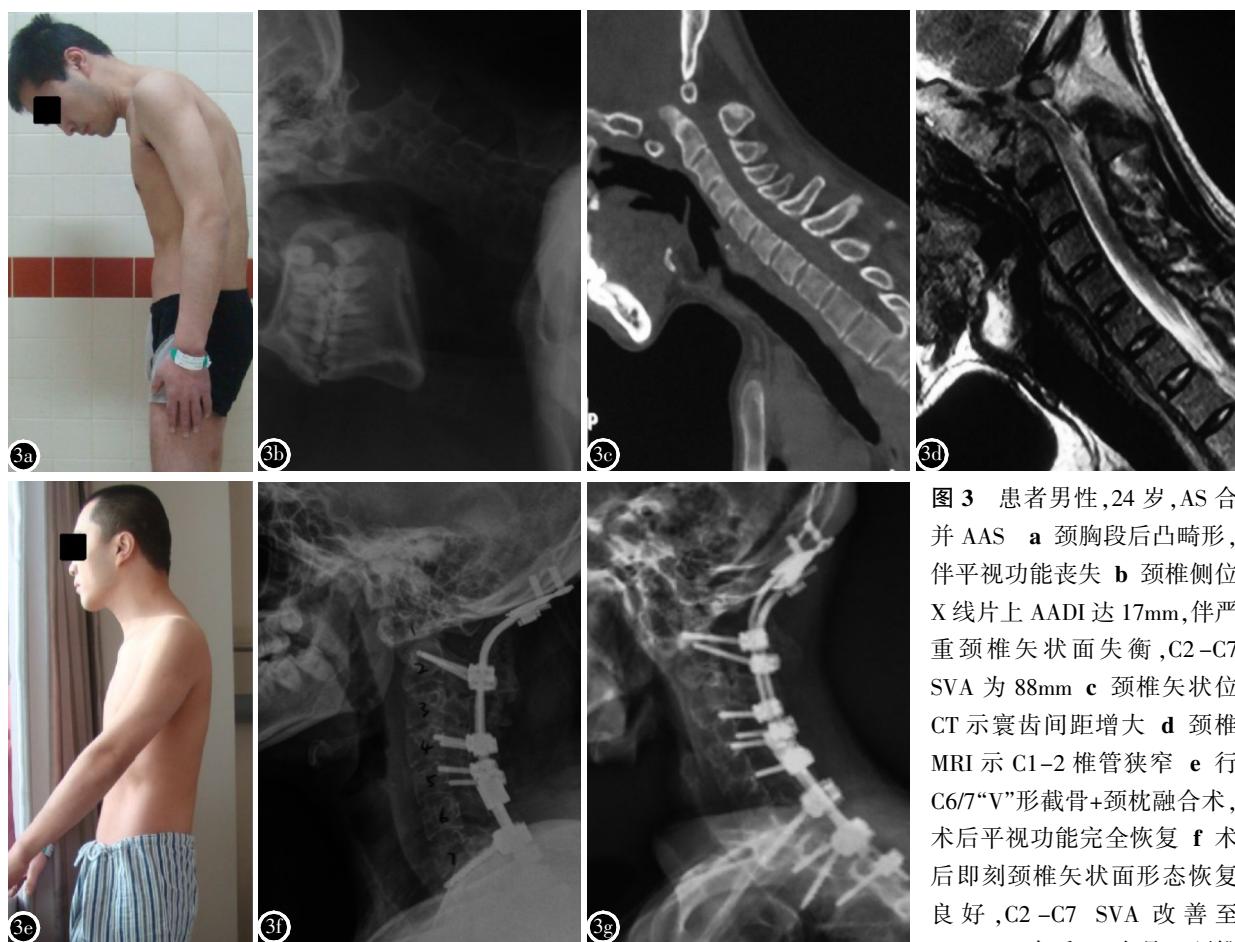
患者男性，24岁，AS 合并 AAS a 颈胸段后凸畸形，伴平视功能丧失 b 颈椎侧位 X 线片上 AADI 达 17mm，伴严重颈椎矢状面失衡，C2-C7 SVA 为 88mm c 颈椎矢状位 CT 示寰齿间距增大 d 颈椎 MRI 示 C1-2 椎管狭窄 e 行 C6/7“V”形截骨+颈枕融合术，术后平视功能完全恢复 f 术后即刻颈椎矢状面形态恢复良好，C2-C7 SVA 改善至 23mm g 术后 28 个月，颈椎侧位 X 线片示内固定在位，融合情况良好，无明显矫正丢失
